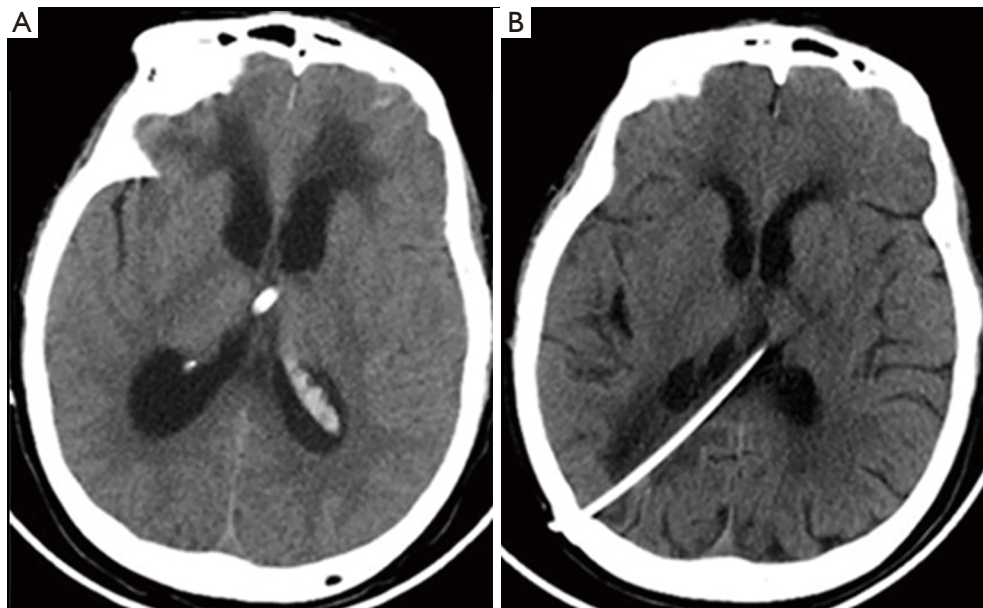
CT findings after treatment. (A) On day 12 of the hospitalization, CT scan before EVD removed showed the contractible bilateral ventricles; (B) follow-up CT performed 6 months after insertion of ventriculoperitoneal shunt revealed that the size of the ventricle has basically returned to normal with the catheter. EVD, external ventricular drain.
